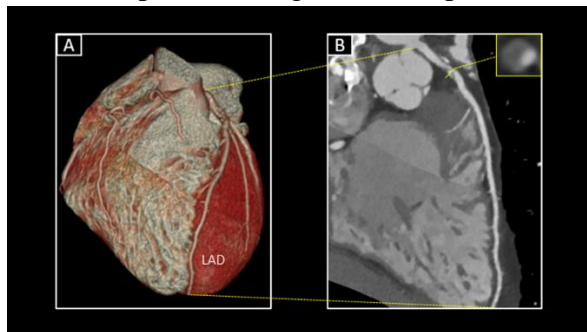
Obstructive CAD – significant stenosis on LAD (left anterior descending artery) diagnosed by coronary CTA
